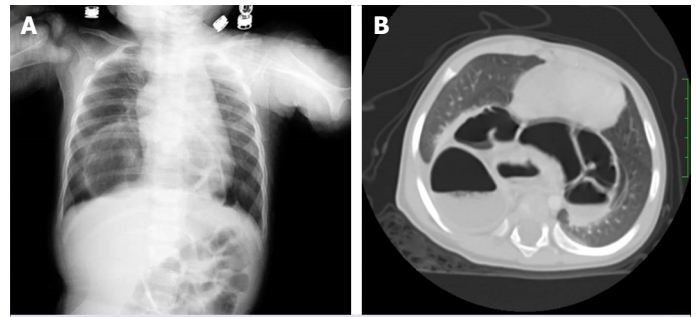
(A) A-P chest X-ray of patient 1 showing mid-thoracic air loculations resembling intestinal gas. The lesion looks like a Morgagni hernia. Gastric air is not seen at its usual location. (B) Computed tomography of the same patient shows posteriorly placed diaphragmatic defect that includes intestinal structures. This patient had type IV HH.
